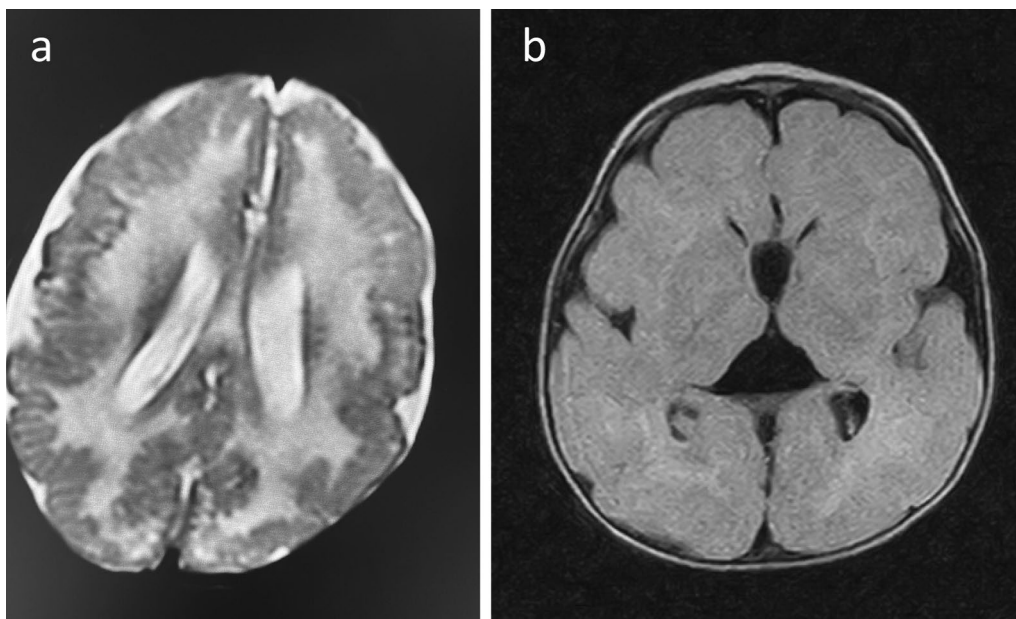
a Axial T2 brain MRI of patient V5 displaying diffuse high signal intensity on T2 in the white matter alongside posterior polymicrogyria and pachygyria. b Axial FLAIR brain MRI of patient V6 revealing pachygyria and lissencephaly
